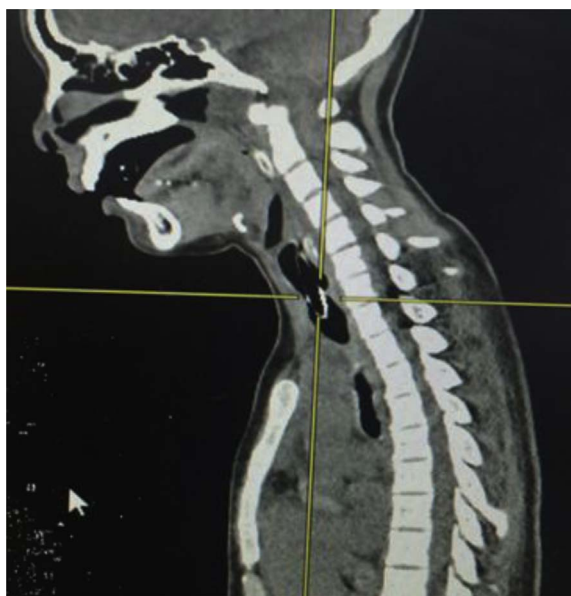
CT Thorax pre intervention, Sagittal plane: Trachea narrowing 4.6 cm from hyoid bone, 0.8 cm length and 9.5 cm from hyoid bone, 8.7cm length. Right main bronchus narrowest diameter was 0.3 cm.
